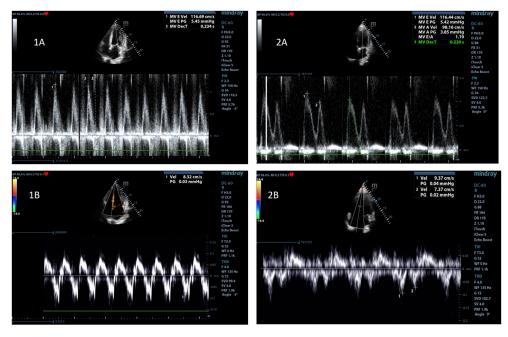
b.10. Evaluation of diastolic function before (1A: fused E and A waves of 116 cm/s, PW doppler 4; 1B:  $e'_s < a'_s$  in tissue Doppler) and after surgery (2A: E>A, PW Doppler,  $e'_s > a'_s$  in tissue Doppler)
